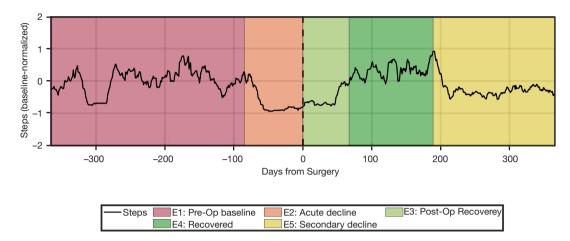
Time series of steps/day and peri-operative clinical stages in an example patient. A 66-year-old patient underwent right-sided L4–L5 hemilaminectomy, medial facetectomy, and microdiscectomy. She presented 3 months earlier with new-onset intractable right leg pain rendered her unable to walk prior to surgery. MRI showed disc herniation and compression of right L5 nerve. The onset of her radiculopathy is detected as Epoch 2 (acute decline) and her progressive loss in mobility is reflected in the gradual decrease in normalized activity (average of 64 steps/day). The patient had decreased mobility during Epoch 3 (post-operative recovery) with an average of 78 steps/day. After 67 days, the patient transitioned to Epoch 4 (recovered) and had increased activity (average of 208 steps/day). This correlates with the patient's report of significant improvement in pain symptoms at the 3-month post-operative follow-up visit. The patient presented again 10 months after surgery complaining of similarly disabling right leg pain. A subsequent MRI of her lumbar spine showed re-herniation at L5. This secondary decline correlated well with the algorithm's automatic identification of Epoch 5, which indicated decreased mobility to an average of 120 steps/day starting at post-operative day 189. The patient elected not to proceed with a second surgery at the time due to her social situation at home. MRI, magnetic resonance imaging.
